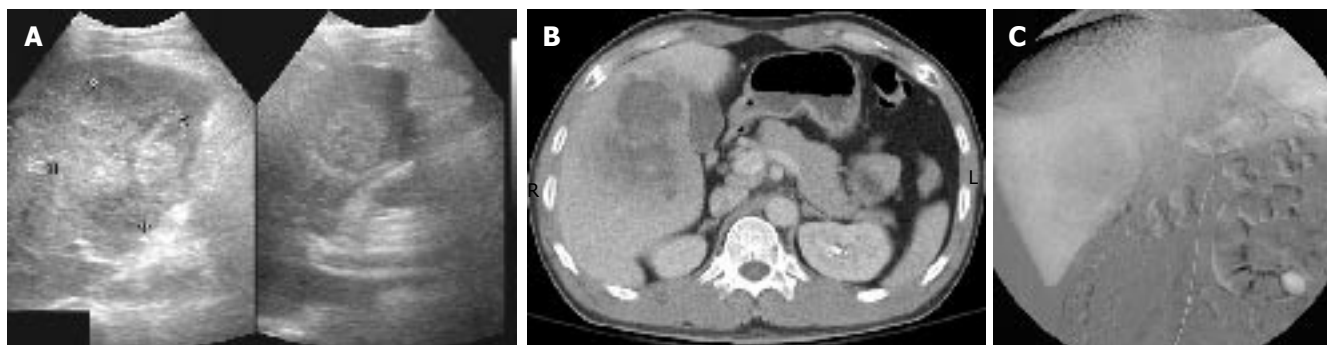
A: Abdominal ultrasonography (US) shows a mixed echoic mass about 7.8 cm occupying S5 of right lobe of the liver; B: Abdominal computed tomography (CT) shows a 7 cm x 9.5 cm irregular mass with nonhomogeneous density and mild delayed enhancement in the central zone of the tumor near the gallbladder, at S5 of right lobe of the liver; C: Angiography shows a large tumor with neovascularity and stretching the feeding arteries, located at S5 of right lob of the liver.
